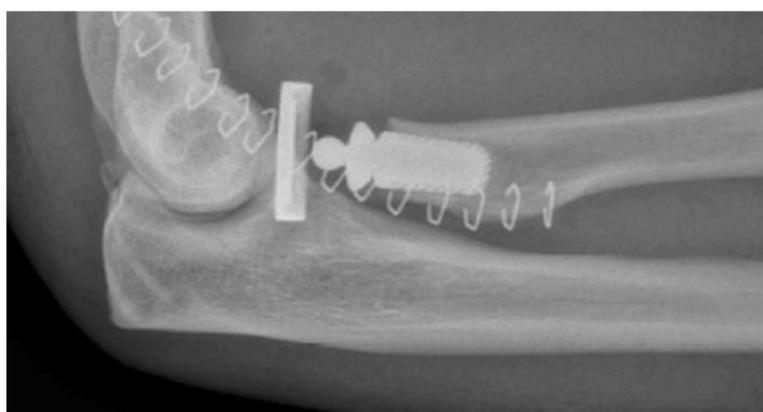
Lateral x-ray of the left elbow showing correct positioning of the prosthesis.
